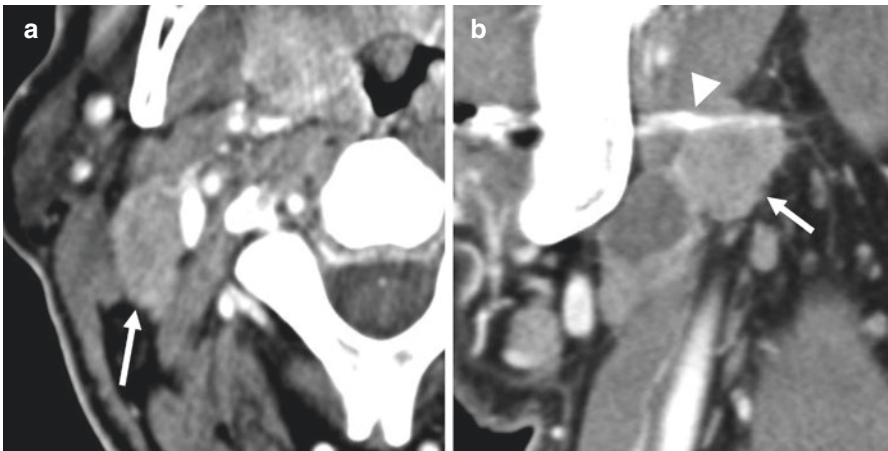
Oropharyngeal SCC with right level 2 adenopathy. Axial (a) and oblique coronal (b) CT show irregular nodal capsule contour with nodularity (arrows). Arrowhead on image (b) points to artifact from dental amalgam. Pathology revealed ECS
